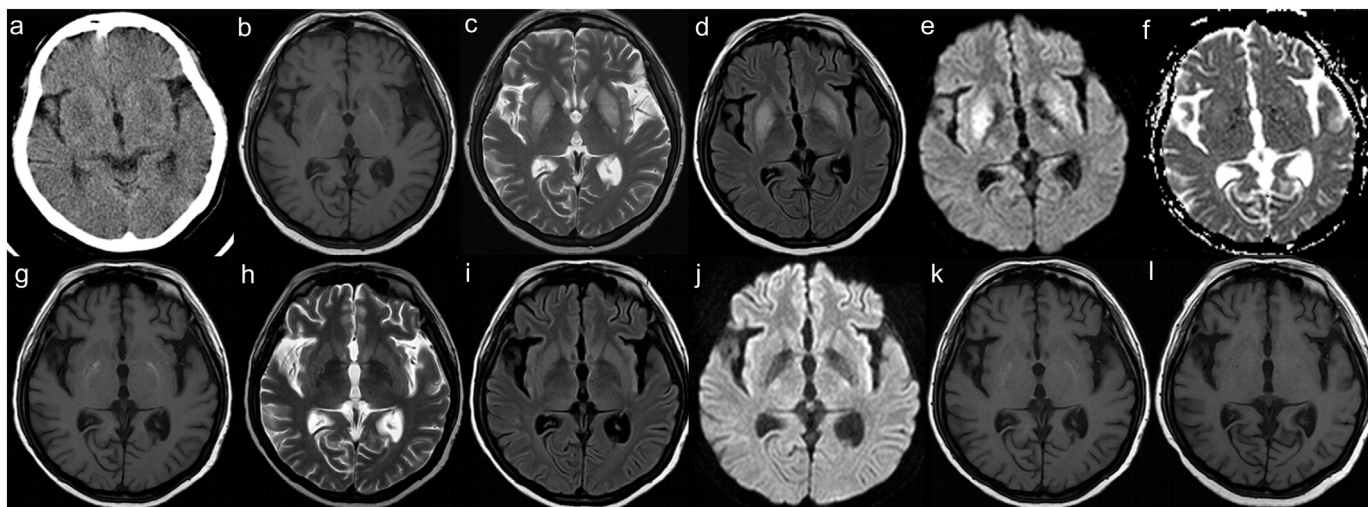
Brain CT scan shows bilateral symmetric low densities in both basal ganglia (a). T1-weighted MRI axial view shows symmetric hypointensity on bilateral basal ganglia with high signal in medial peripheral part (b). T2-weighted MRI (c), FLAIR image (d) and DWI (e) show hyperintensity on bilateral basal ganglia. Apparent diffusion coefficient map does not demonstrate signal change in either of the basal ganglia (f). Repeat MRI 2 months after symptom onset shows the symmetric hyperintensity on part of bilateral basal ganglia remains stationary on T1-weighted image (g) but marked regression of most of the symmetrical basal ganglia lesions on T2-weighted image (h), FLAIR image (i) and DWI (j). Follow-up MRI 6 months later shows partial regression of the lesion on T1-weighted image (k), and total resolution 2.5 years later (l).
